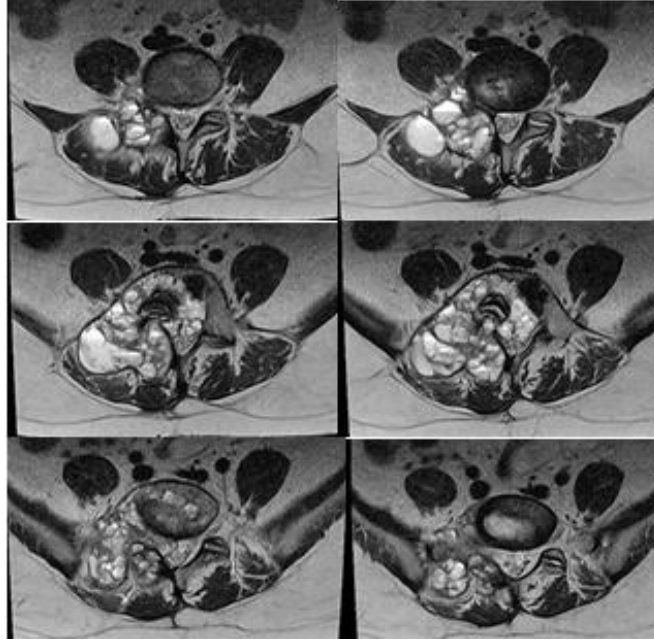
MRI of the spine / March 2023- The inhomogeneous, mostly high-signal T1 multicystic mass, encompassing the body of L5 on the right with the corresponding peduncle, arch and transverse process, has the following dimensions - anteroposterior about 6.1 cm, transverse 7.8 cm - and craniocaudal 5.1 cm, with the increase being at the expense of the transverse dimension/towards the body medially and to the left.
